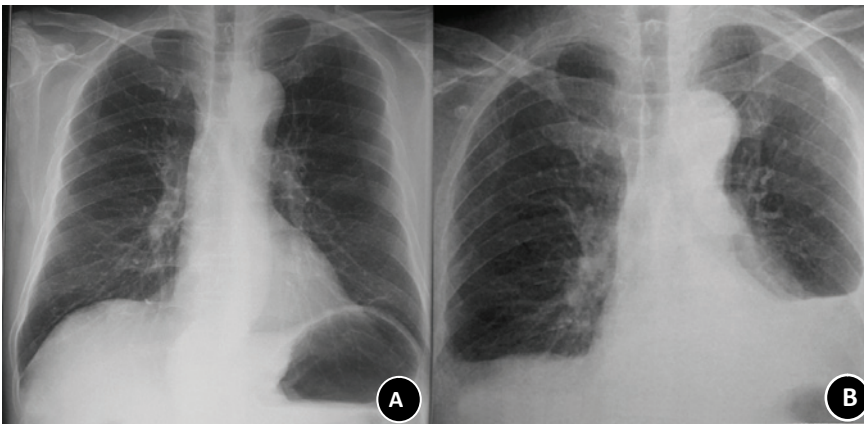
Comparison of the chest radiographs before (A) and 7 days after the surgery (B). In contrast to A, B reveals a corpulent mediastinum, vague costophrenic angles and heart shadow, which might be resulted from the anastomotic leakage into the mediastinum and subsequent bilateral reactive pleural effusion.
